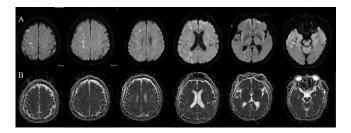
Magnetic resonance imaging after admission: Diffusion-weighted image showed multiple patchy and punctate high signals in the right frontal, temporal and parietal lobes, the right basal ganglia and the right corona radiata centrum semiovale (A) and low signal intensity on the apparent diffusion coefficient map (B).
